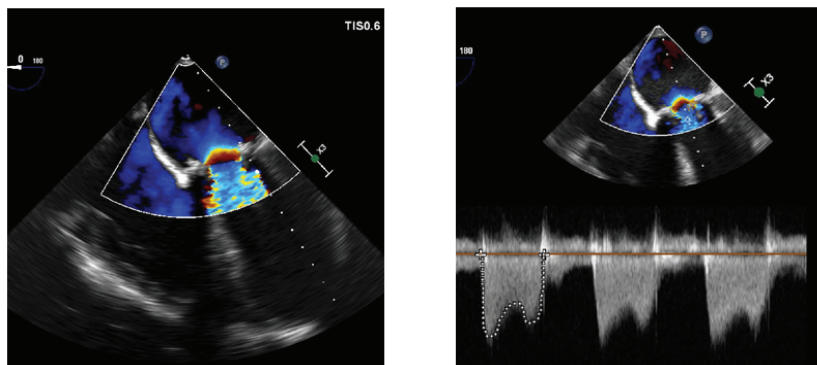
Post-cardiopulmonary by pass intraoperative TEE images of bioprosthetic mitral valve with turbulent inflow by colour Doppler (left panel) and a mean gradient of 12 mmHg by continuous wave Doppler (right panel). A second pump run was then undertaken to place a mechanical mitral valve with a mean gradient 3 mmHg.
